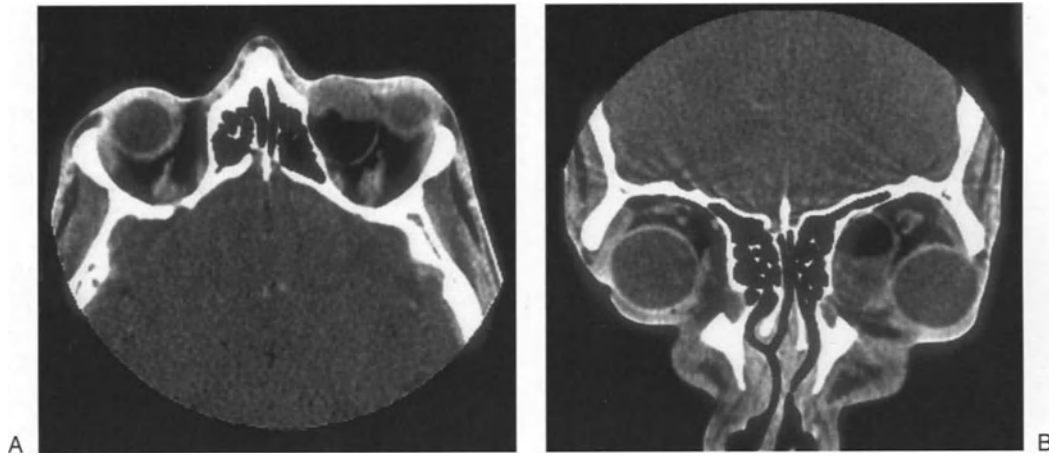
Orbital dermoid – this CT scan, axial (A) and coronal (B), is an imaging study of an extraconal mass in the superomedial portion of the left orbit. It has fatty and solid
